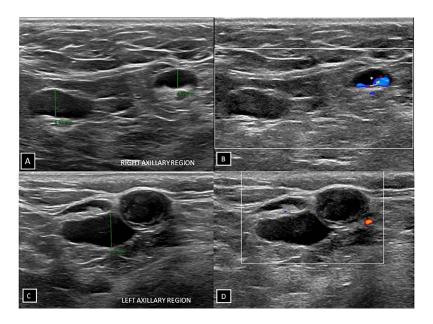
Gray-scale and color Doppler ultrasound. (A and B) Right axillary lymph nodes are observed round, with hypoechoic cortical thickening of 7 mm and (* asterisk) shows nonhilar blood flow. (C and D) Left axillary lymph nodes contain eccentric displaced hilum, round, or oval morphology and 8 mm thickened and hypoechoic cortex.
